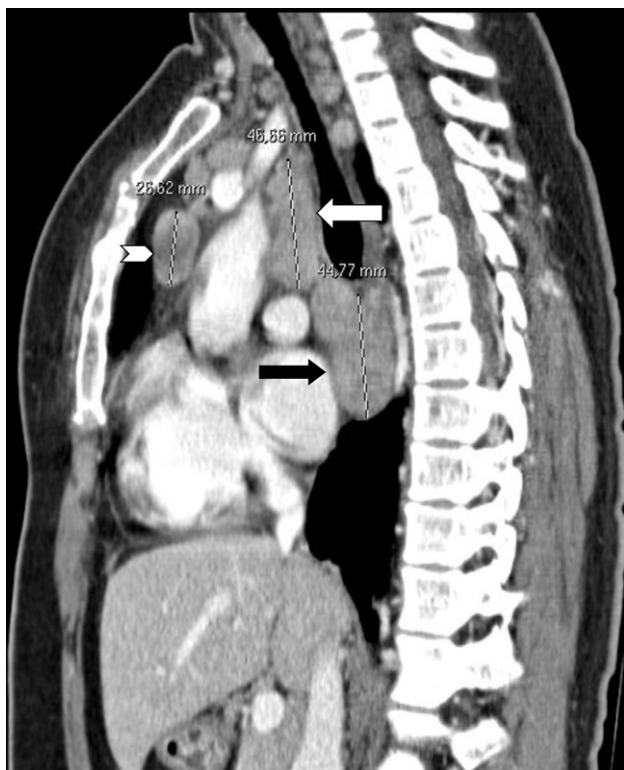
Contrast-enhanced CT of the chest (sagittal view) from a 41-yr-old female sarcoidosis patient showing a continuum of lymph nodes in the right paratracheal area (stations #2R through #4R, white arrow) and in the subcarinal area (stations #7 through #8R, black arrow). A long lymph node in the anterior mediastinum (station 3°, red arrow) is also visible.
